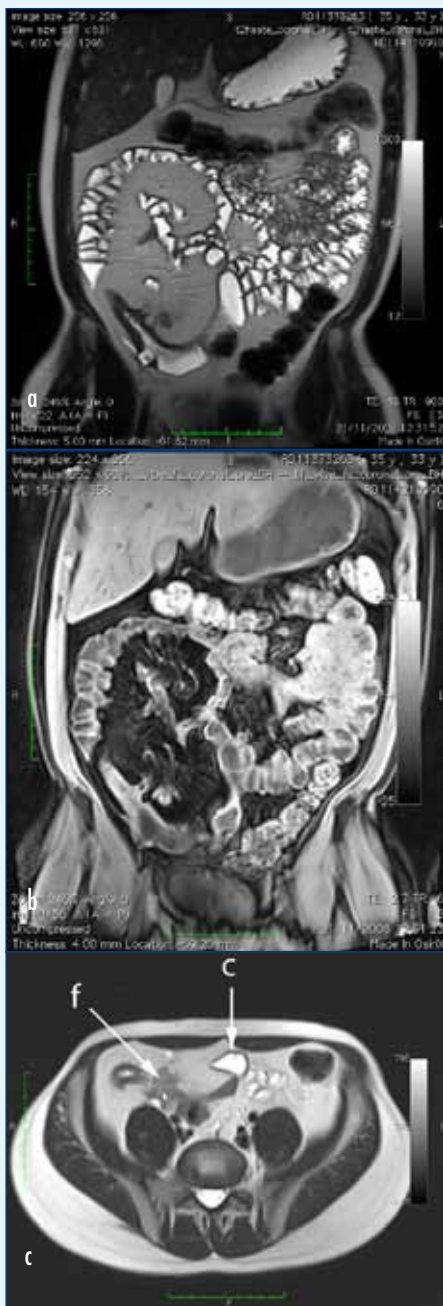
Advanced Crohn's disease. Magnetic resonance imaging shows wall thickening in the terminal ileum, proliferation of mesenteric fat, a focal collection in right iliac fossa (c) and small fistulous tract (f) to the sigmoid colon.
